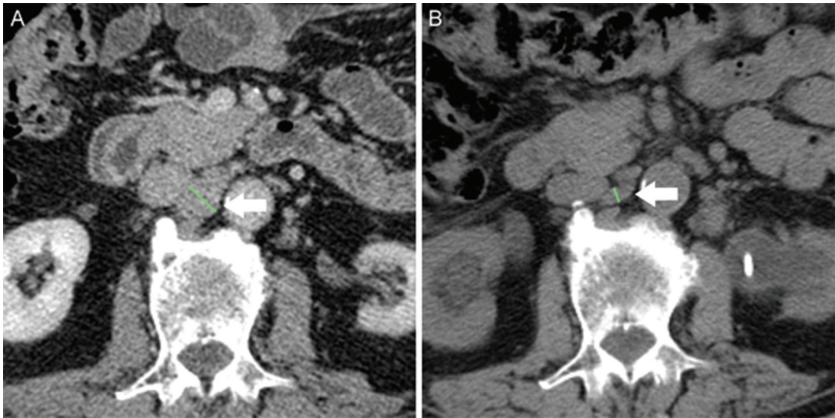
Partial response in patient no. 8 (by RECIST 1.1). (A) Contrast-enhanced computed tomography (CT) scan showing 16 mm periaortic lymphadenopathy (diagonal green line, indicated by white arrow); (B) non-enhanced CT scan 2 years after treatment showing a 50% decrease in the short axis of the lesion, which had become too small to be considered pathological.
